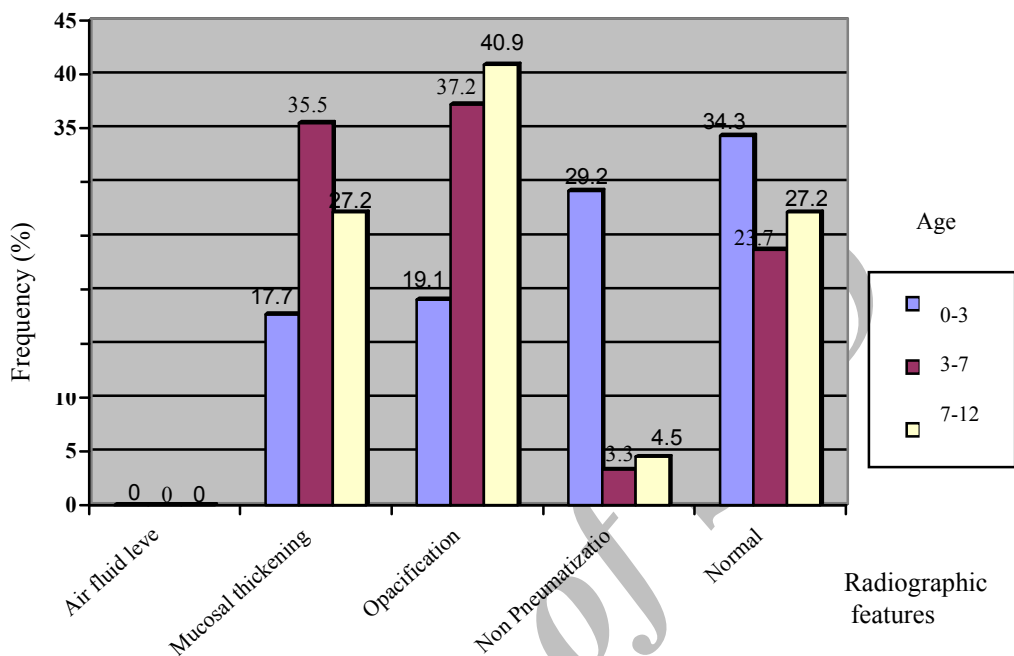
Distribution of patients, according to radiographic.
